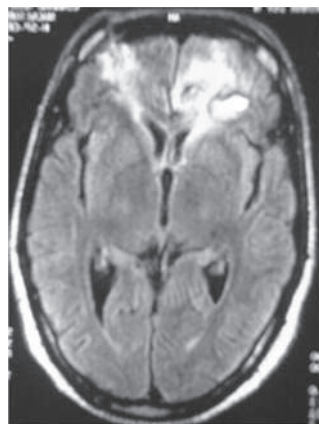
MRI brain FLAIR images showing bifrontal patchy contusions
